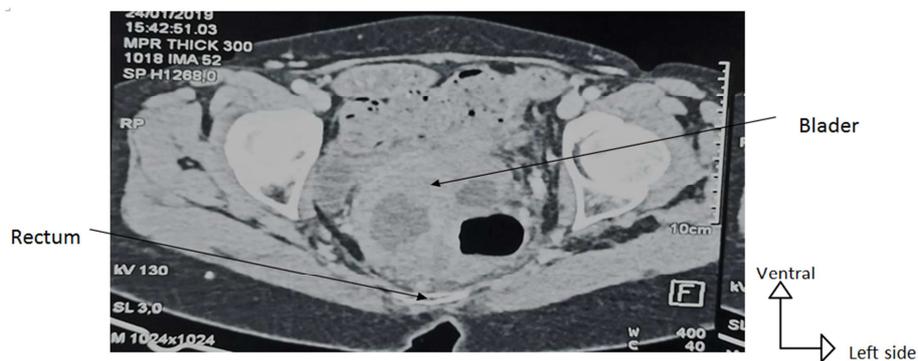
Transverse axial section showing a left ovarian mass and rectal thickening on MRI.
